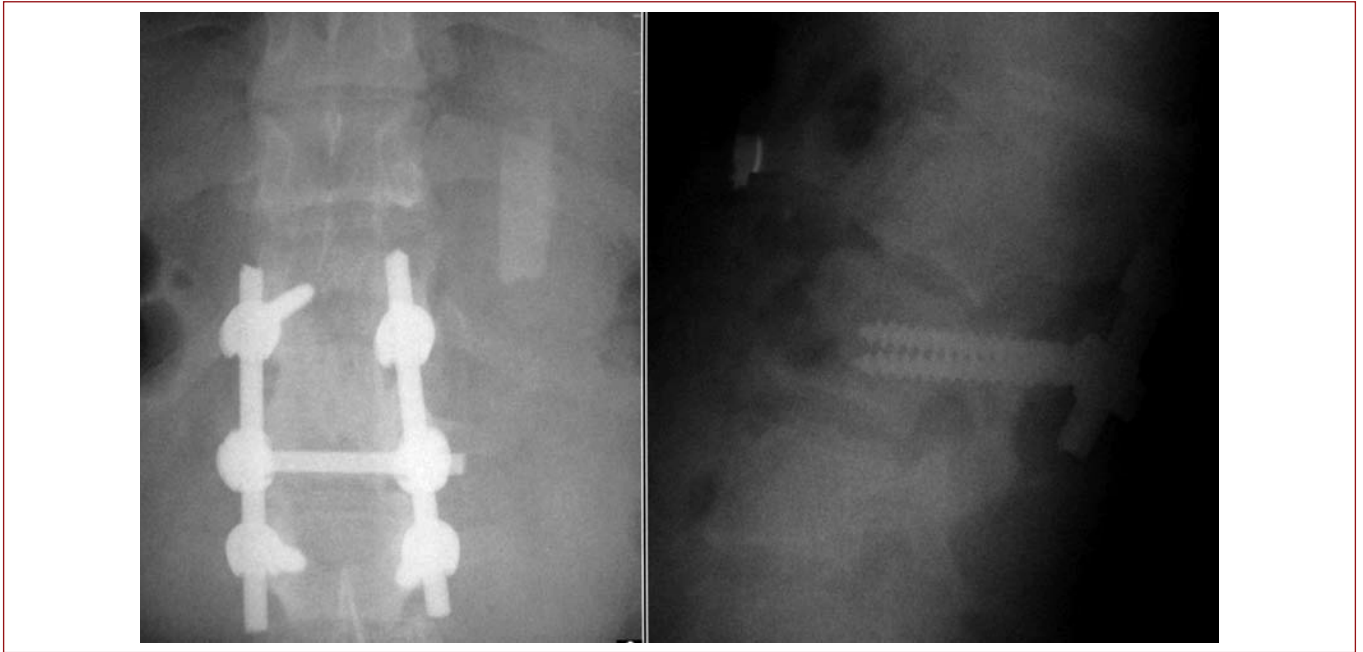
Postoperative last follow-up X-ray.
